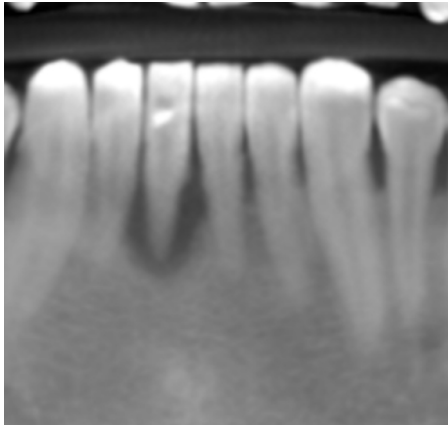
Cone beam computed tomography scan showing sagittal section.
